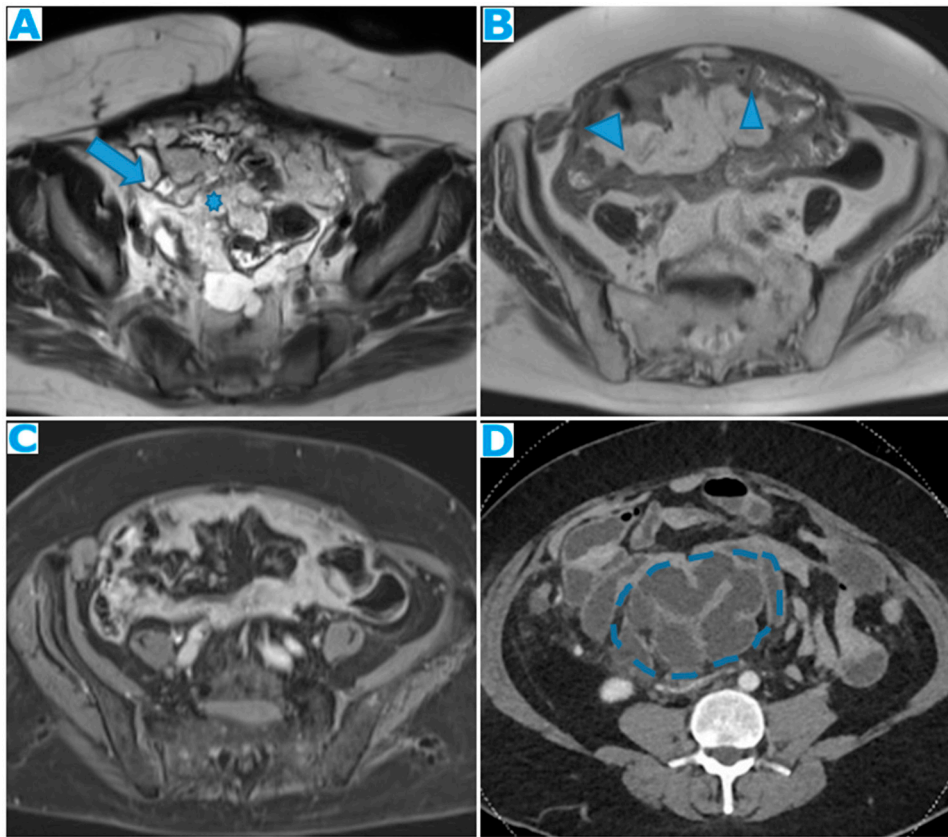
Axial T2WI (A). PC from mucinous adenocarcinoma of the uracus: Notice the hyperintense mesenteric deposits (*) (signal due to mucin content) and how the SB loops appear separated and angulated (arrow). Axial T2WI (B), axial CE portal phase FST1WI (C). PC from breast carcinoma: Mesenteric deposits (arrowheads on B) make SB loops appear thickened and separated. Notice how deposits are more conspicuous on T2WI due to its high tissue contrast. Axial CE-CT (D). PC from ovarian carcinoma: Clustered small bowel loops as the end point of mesenteric seeding.
